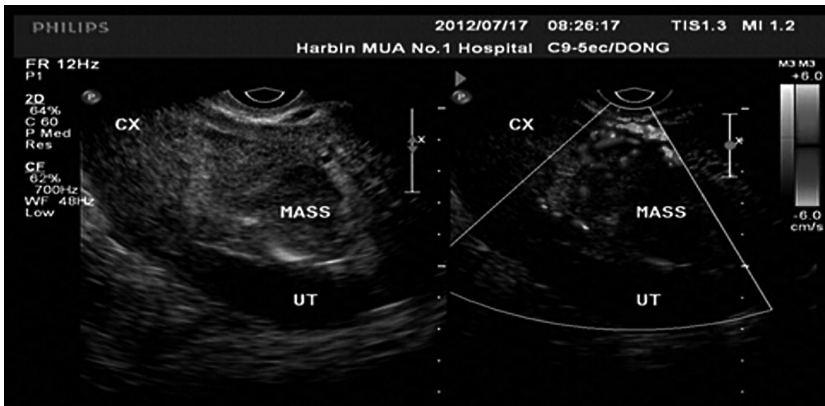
Endometrial cancer by transvaginal ultrasound and color Doppler flow imaging.
